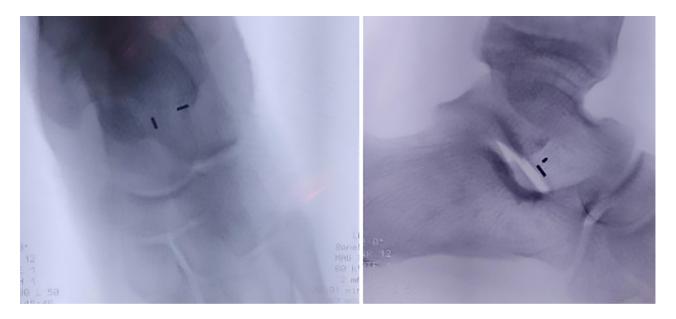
Postoperative X-rays of subtalar arthroereisis with the PitStop® PEEKdevice.
